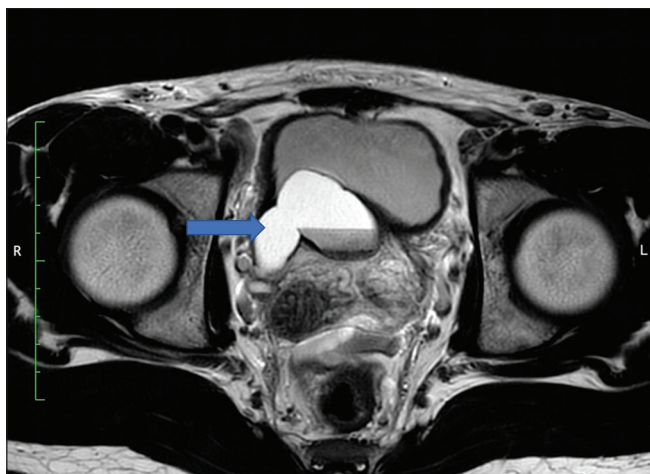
T2-weighted axial section image showing a lobulated cystic lesion at a right posterolateral aspect of the urinary bladder. The cystic lesion shows a fluid debris level, suggesting a seminal vesicle cyst. The cyst is causing compression on the adjacent urinary bladder
